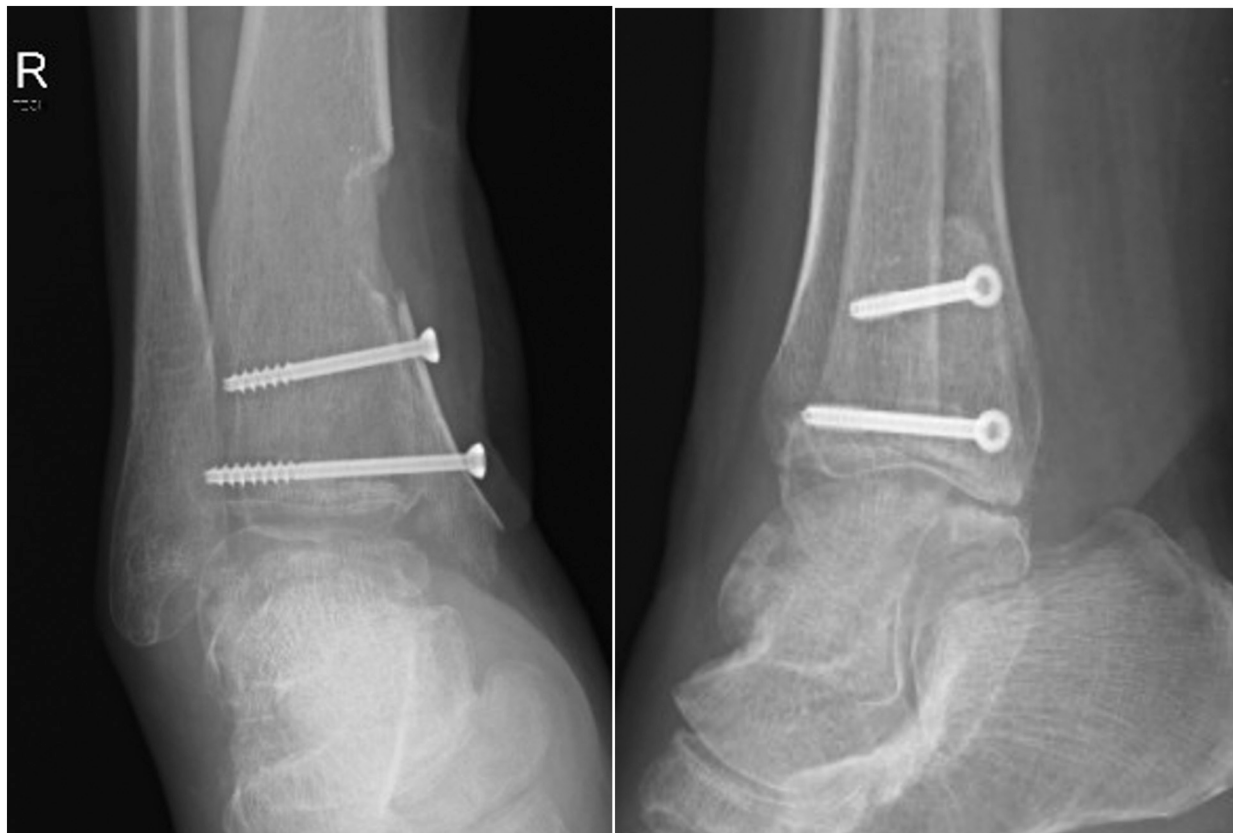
The radiographs from 6-month follow-up showed consolidation of the sliding bone block.
